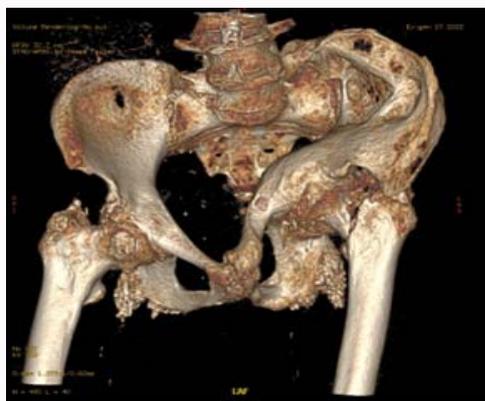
3D CT scan of the pelvis performed at the emergency department.
